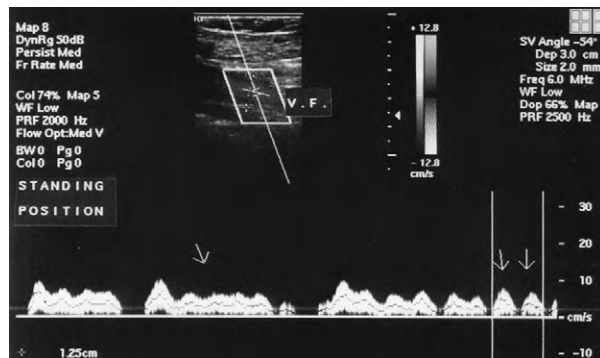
Blood flow in the femoral vein in spectral Doppler mode in the upright position (two arrows indicate the waves during breath-holding).
